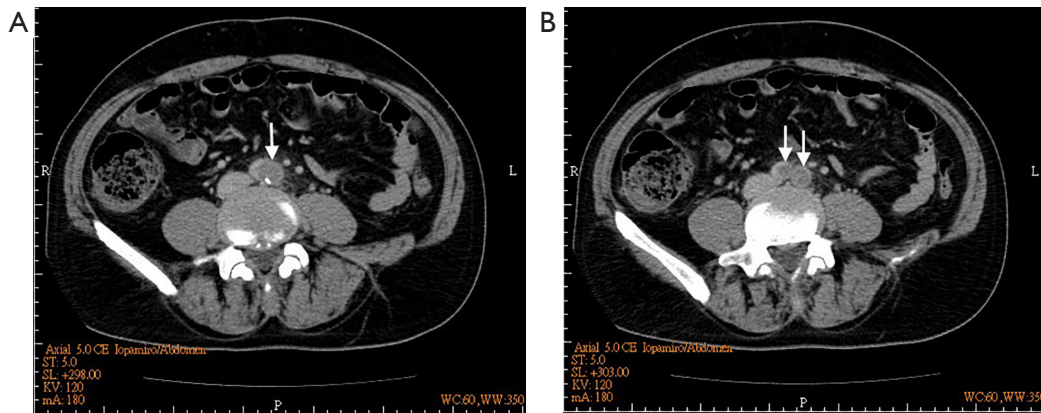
Axial view of contrast-enhanced abdominal computed tomography (CT) showed a huge aortic thrombus at the level of aortic bifurcation (arrows).
